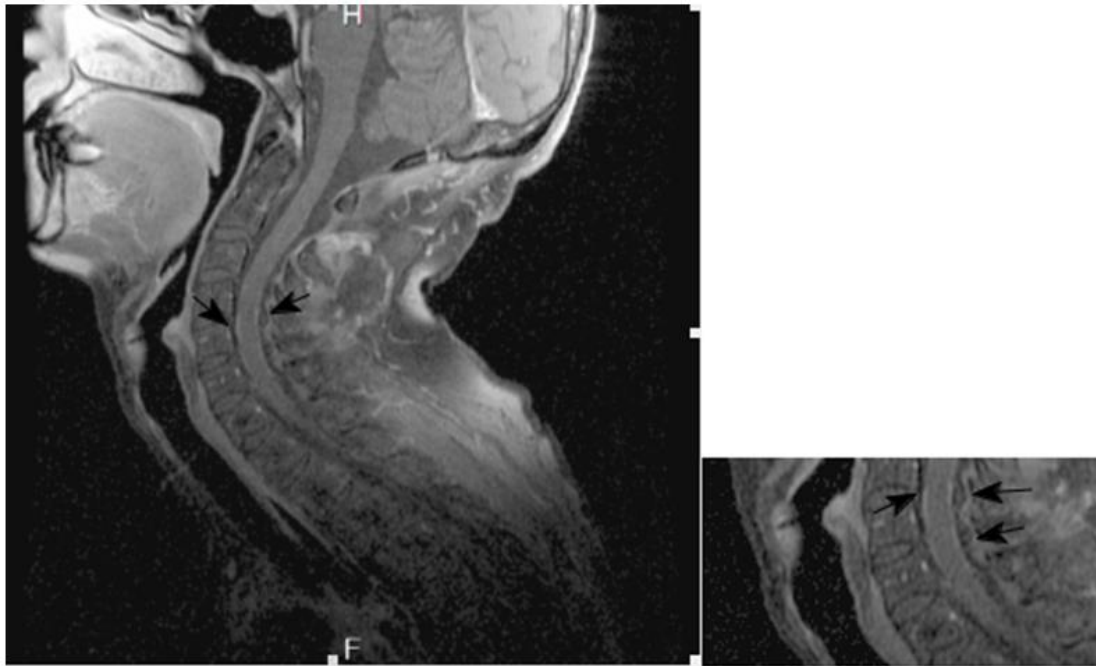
SAG T1 FLAIR Fat Sat +C MR postcontrast images of cervical spinal axis after 4 months of RT and after 3 months of targeted therapy alone
